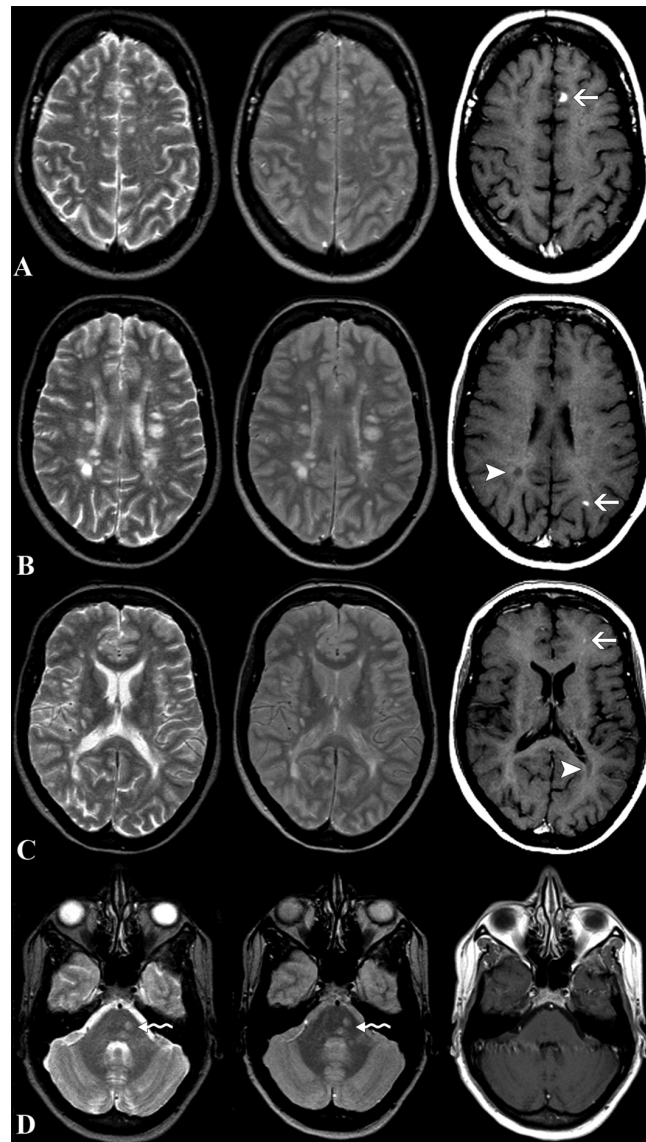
MS related abnormalities. Typical MS lesions on MR images at different levels. Displayed are T2- (left), intermediate- (middle), and gadolinium enhanced T1- (right) weighted spin-echo MR images. Multiple T2-lesions are shown, including (juxta) cortical-, periventricular-, and infratentorial lesions (waved arrow). Several T2-lesions are represented as hypointense lesions ('black holes') on the T1-weighted images (arrowheads). The T1-weighted images also show three enhancing lesions (arrows), including one (juxta) cortical lesion (arrow, row A).
